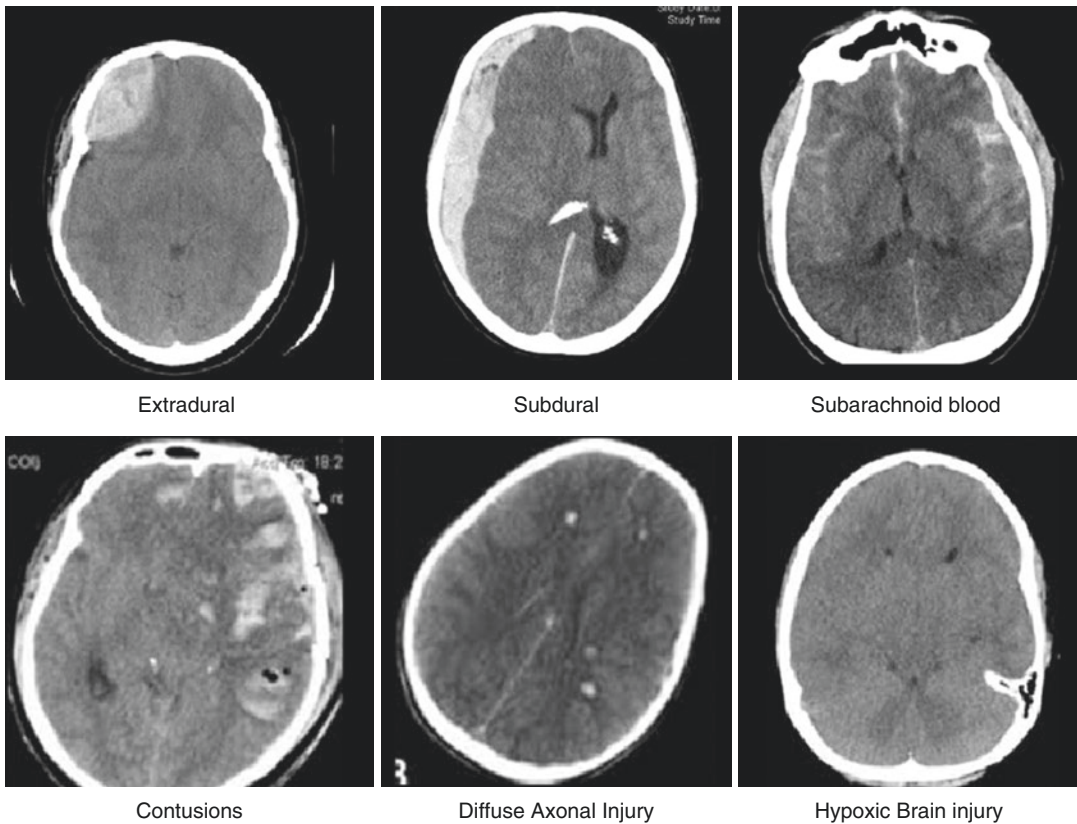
A collection of CT images demonstrating the main types of TBI
